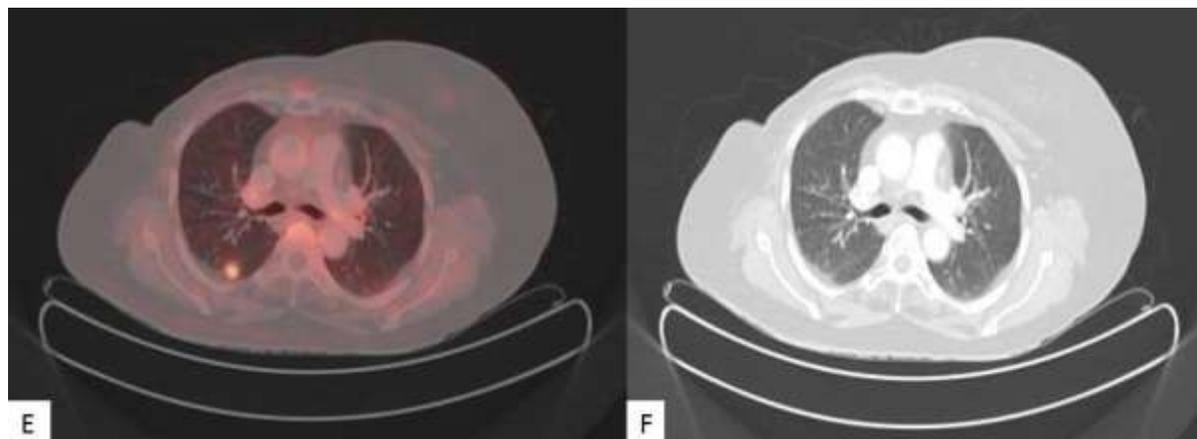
Fused FDG PET CT showing focal FDG uptake in right lung but corresponding CT images does not show any structural abnormality (F)
